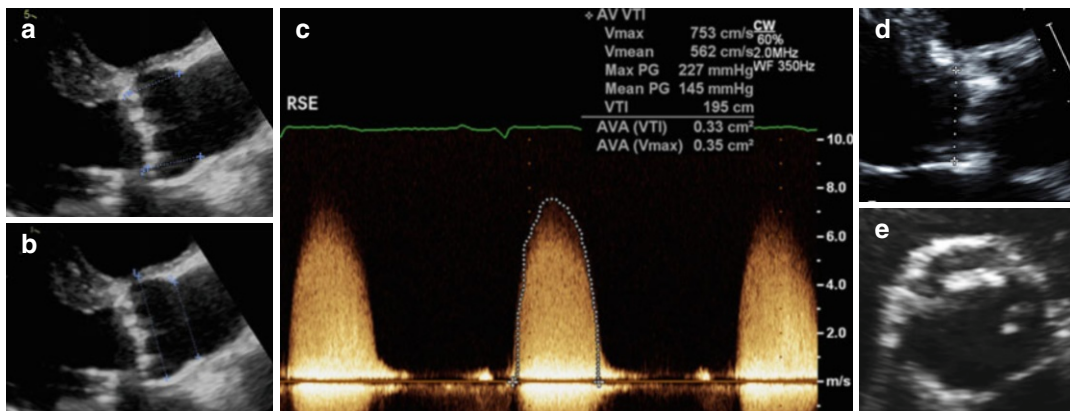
Aortic stenosis echocardiography. (a) Sinotubular height, (b) annular and sinotubular dimensions, (c) CW of the aortic valve, (d) LVOT measurement, and (e) short axis of the aortic valve
